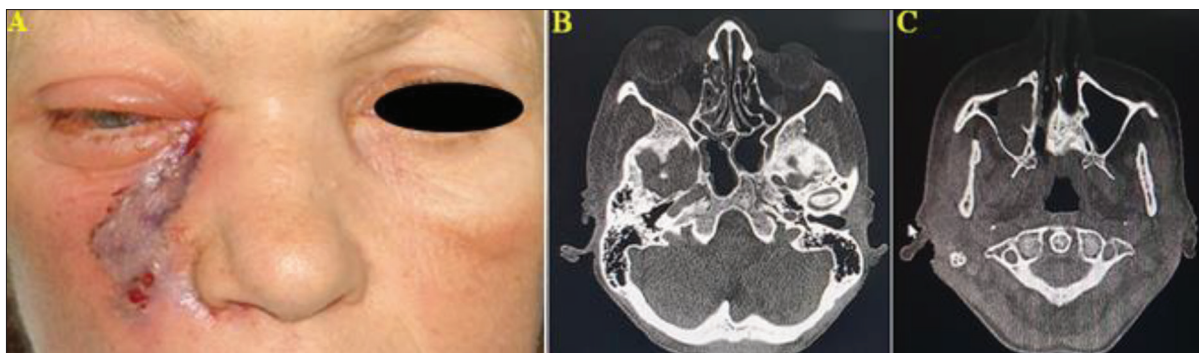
A) Patient presenting with cellulitis of the right side of the face and necrotic skin of paranasal area; B) computed tomography showing right ethmoid cells with heterogeneous density and osteitis; C) computed tomography showing right maxillary sinus with heterogeneous density and osteitis
